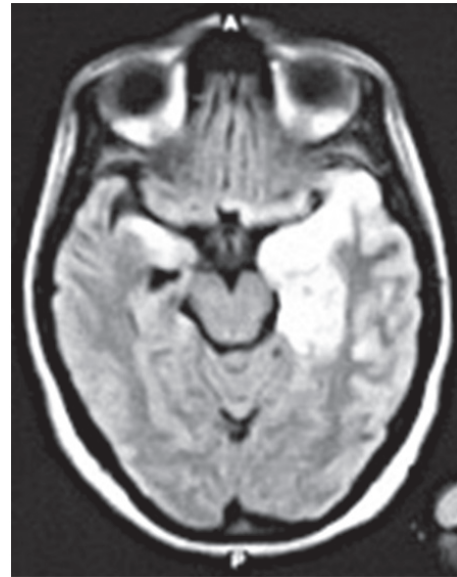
AXIAL FLAIR MRI demonstrating assymmetric high signal intensity in bilateral medial temporal lobe in a patient with acute encephalitis syndrome.
